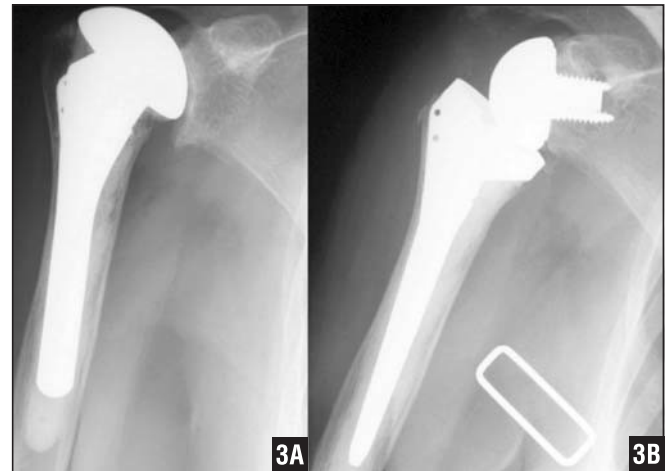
Cranially decentered prosthesis head and deficient rotator cuff (A). Postoperative radiograph (B).
